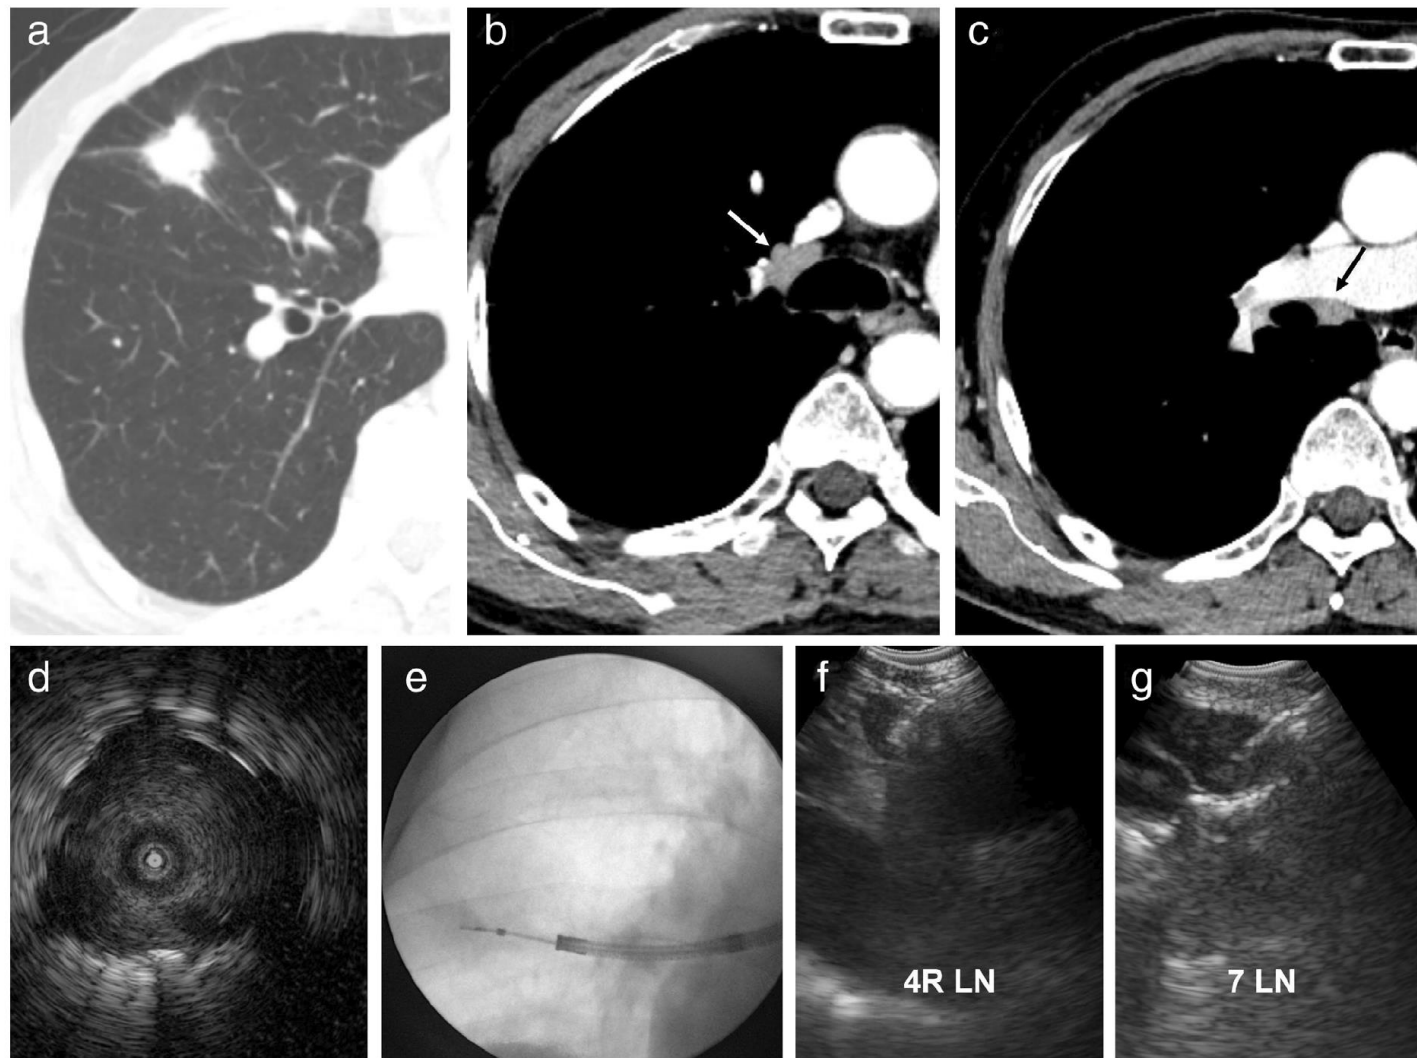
A representative case of the combined procedure with RP- and CP-EBUS. (a) An 18-mm peripheral lung lesion was found in the right middle lobe. (b, c) Axial CT images with a mediastinal window showing enlargements in 4R (white arrow) and 7 (black arrow) lymph nodes. (d) The peripheral lung lesion was found to be “within” on the ultrasonographic image during RP-EBUS. (e) Transbronchial biopsy was performed under fluoroscopy guidance. (f, g) Subsequent transbronchial needle aspiration with CP-EBUS was performed at 4R and 7 lymph nodes. As a result, an adenocarcinoma was found in the right middle lobe, but there was no evidence of mediastinal lymph node metastasis. The patient underwent thoracoscopic surgery and was diagnosed with stage IA lung adenocarcinoma (T1bN0M0). CP-EBUS, convex probe endobronchial ultrasound aspiration; CT, computed tomography; LN, lymph node; RP-EBUS, radial probe endobronchial ultrasound.
